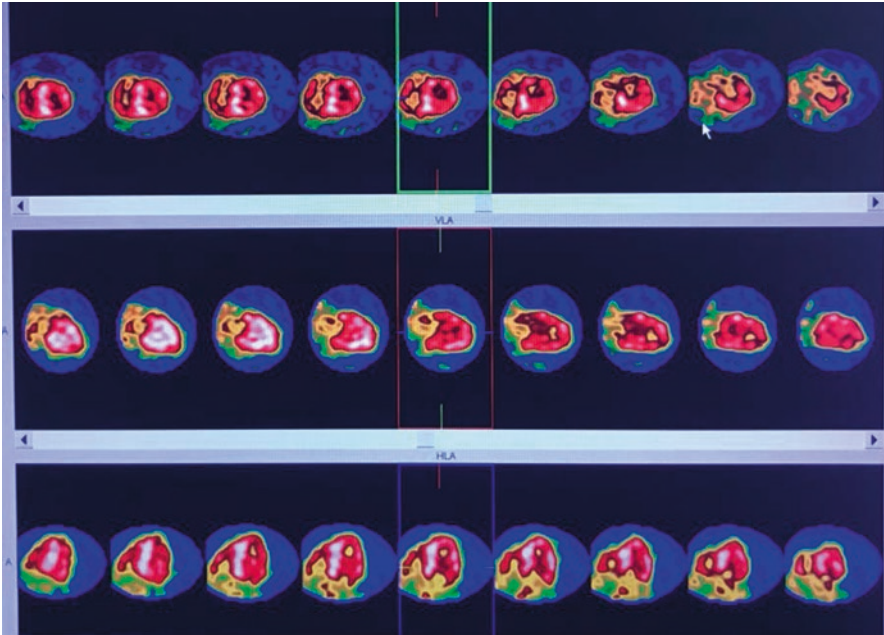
SPECT imaging showing diffuse uptake throughout the myocardium and right ventricle (Author's personal archive)
